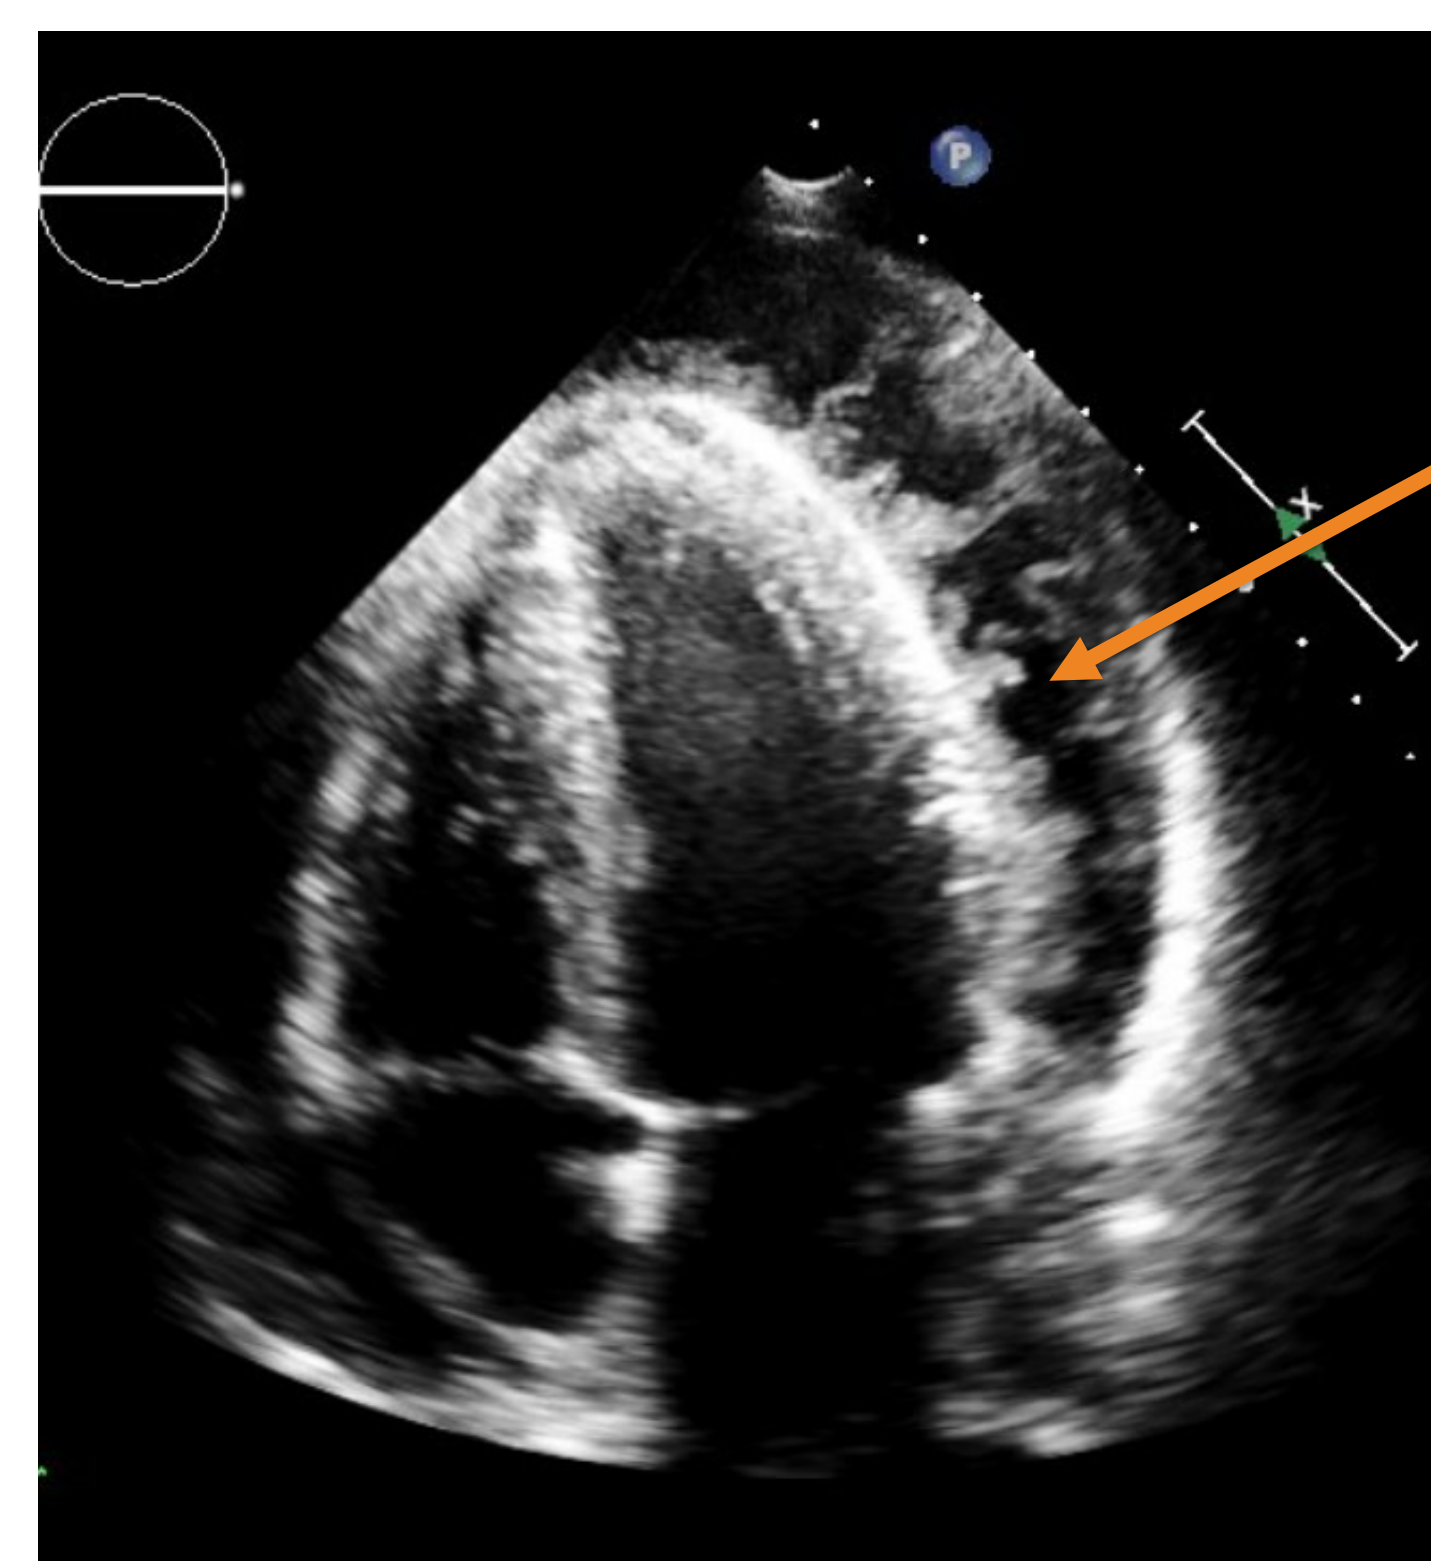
Apical four chamber view of fibrinous exudate within the pericardial space
